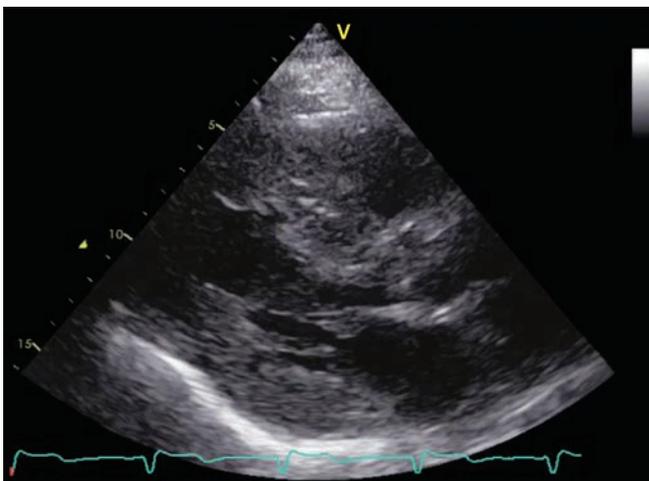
2D TTE. Parasternal long axis view of a 76-year-old active, moderately symptomatic male shows hypertrophied left ventricle.
